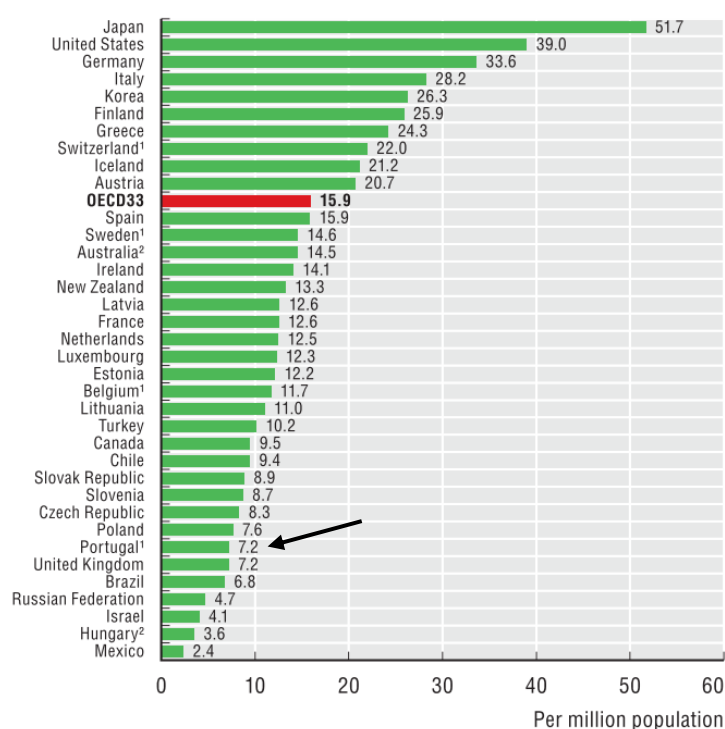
MRI units, 2015 (or nearest year)
